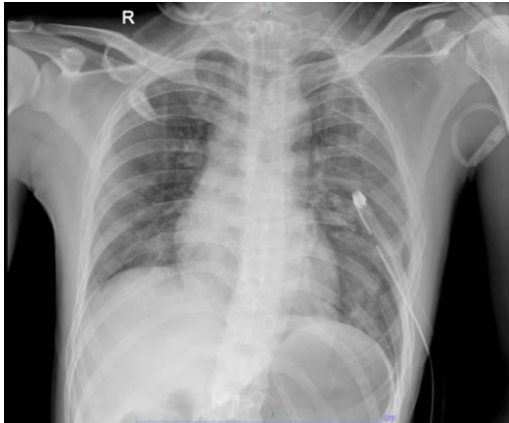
Chest X-ray, left lung abscess.
